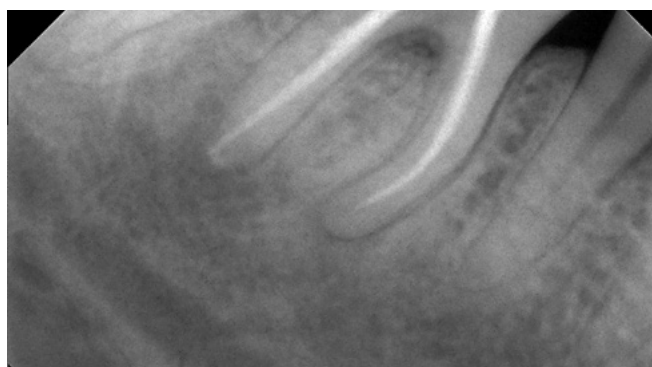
The intraoral X-ray revealed complete healing of the bone tissue around the roots.
